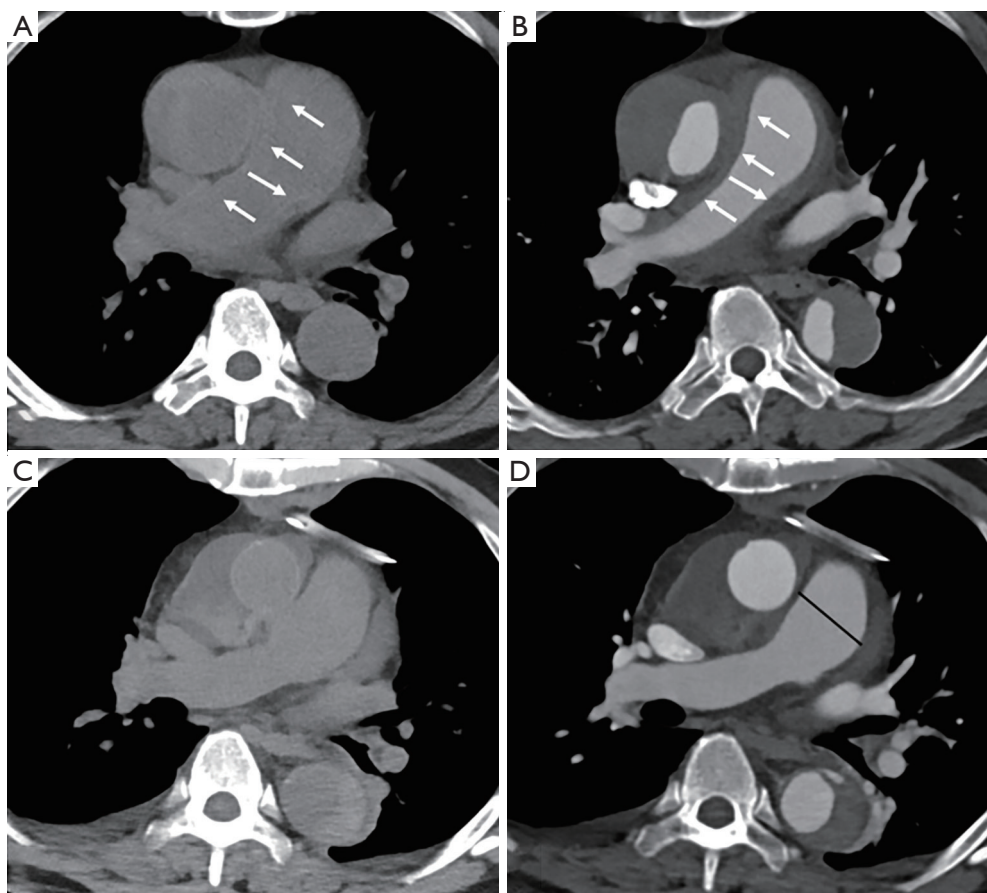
Images for a 51-year-old woman with Grade 1 PAPH. (A) First non-enhanced CT showing a higher attenuation area than that of blood along the wall of the right main PA (white arrows). (B) First CECT showing no contrast enhancement within the area (white arrows). This hematoma induced stenosis of the right main PA. (C,D) Ascending aortic replacement was performed. Follow-up non-enhanced CT and CECT 1 week after the first CT showing disappearance of the hematoma that was due to PAPH, along the wall of the right main PA. Stenosis of the right main PA has improved. We measured the maximum main pulmonary diameter on CECT (black line). PAPH, pulmonary artery periadventitial hematoma; CT, computed tomography; PA, pulmonary artery; CECT, contrast-enhanced CT.
